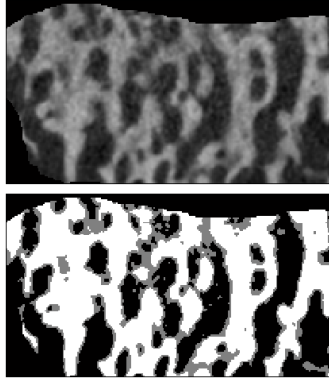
up: μ CT scan of a trabecular bone; down: white region are the bone and grey region are the pixels affected by partial volume effect / poorly mineralized. These grey regions are typically excluded from a conventional analysis of bone structure
